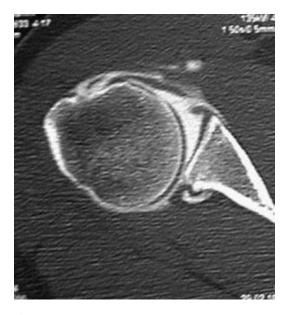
Arthro-CT showing a typical Kim lesion
